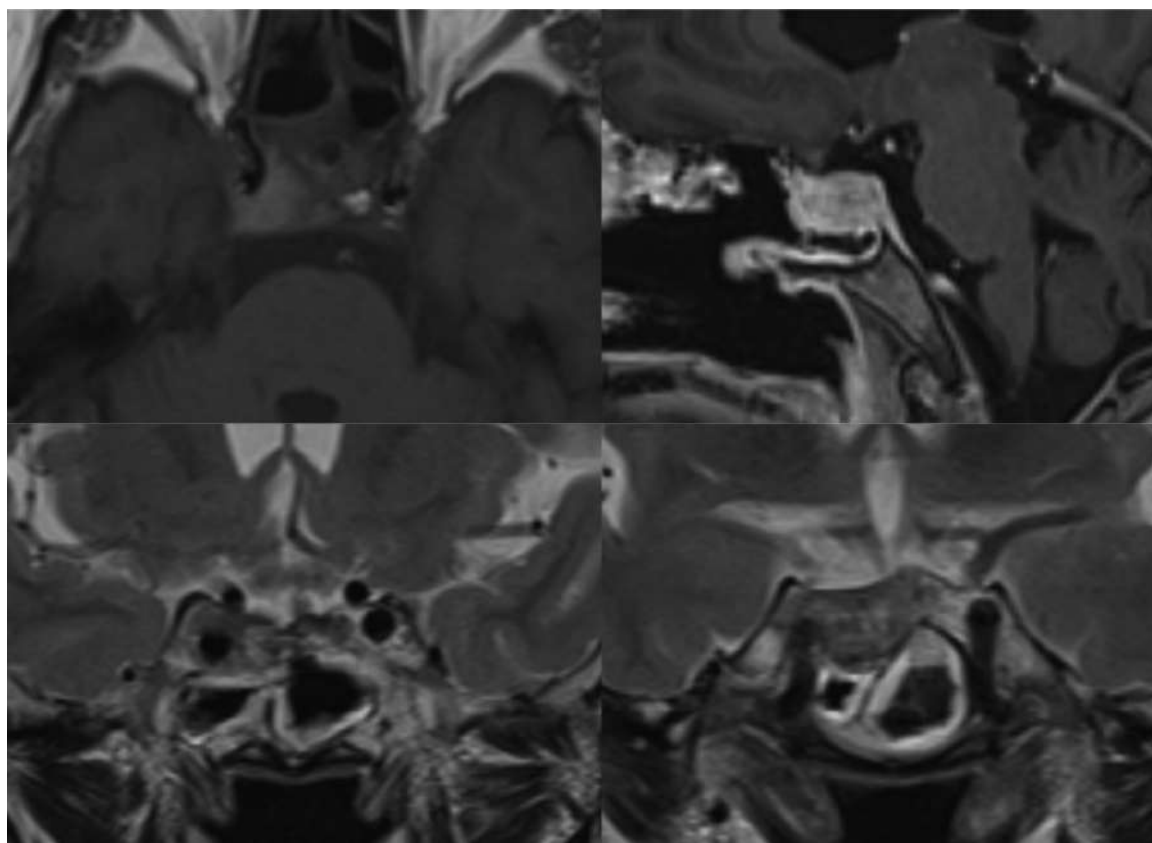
MRI of the patient 4 months following radiotherapy. It is possible to note significant reduction of the volume of the metastasis, and therefore its responsiveness to the therapy. There is a smaller residual lesion hyperintense on T1 imaging in the upper left image that shows contrast enhancement in T1 postcontrast in the upper right picture, predominantly on the right side in close relation with the carotid artery in T2 images, in the lower half of the figure.
